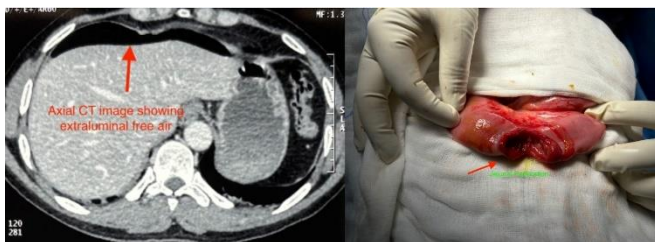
(A) Axial computed tomography (CT) image showing free air. (B) Intraoperative
